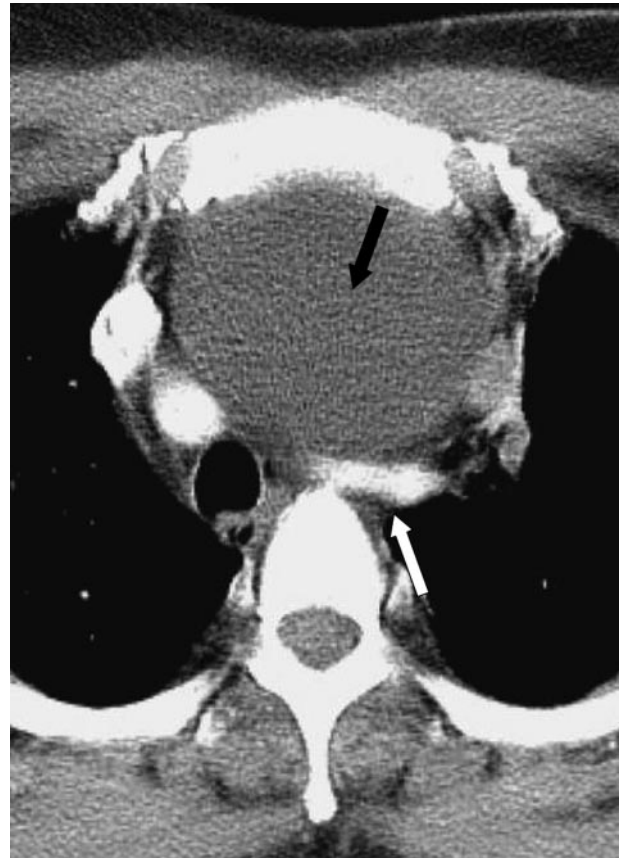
A 54-year-old woman with a pericardial cyst. A contrast-enhanced CT scan shows a large thin-walled cystic mass at the level of the aortic arch (black arrow). The innominate vein is compressed by this mass (white arrow).
